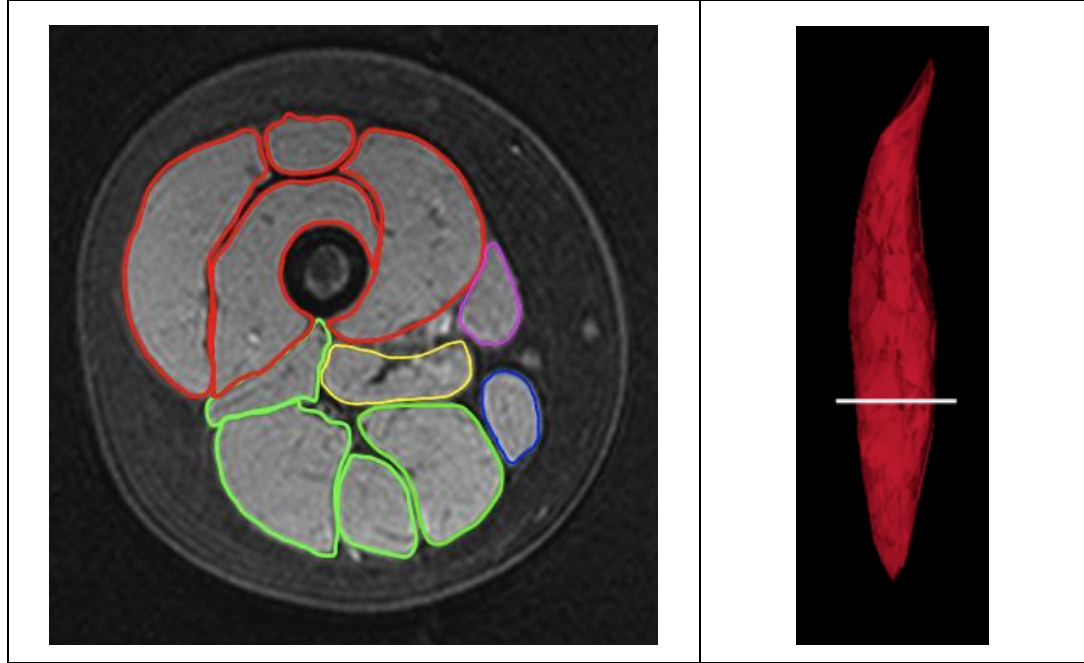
Example MRI image
